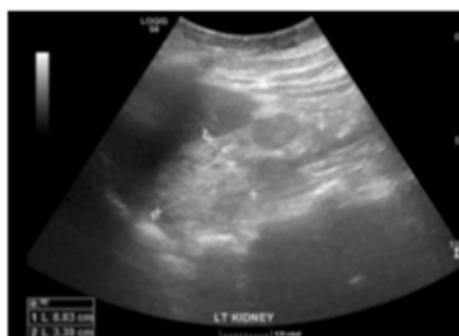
Sonographic progression of chronic kidney disease in one year.
